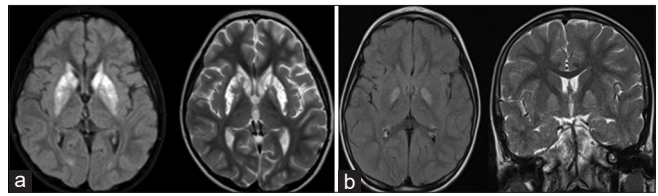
(a) Cranial MRI, case 1 (index case), pathological signal changes in bilateral caudate and lentiform nuclei. (b) Cranial MRI, case 3, pathological signal changes bilaterally globus pallidus
